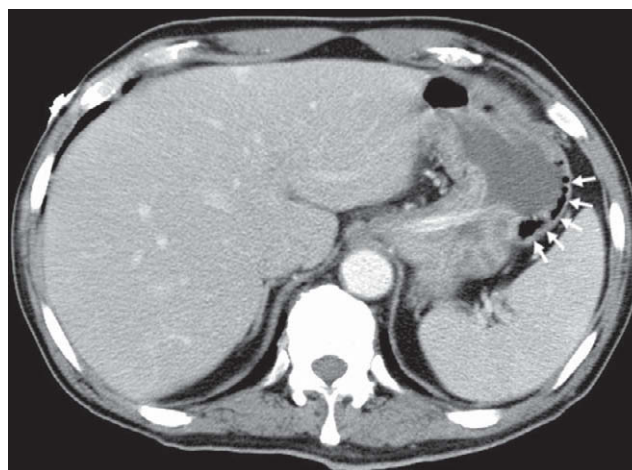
Contrast-enhanced computed tomography of the abdomen showing a collection of intramural gas over the greater curvature side of the gastric body (arrows), indicative of emphysematous gastritis.
